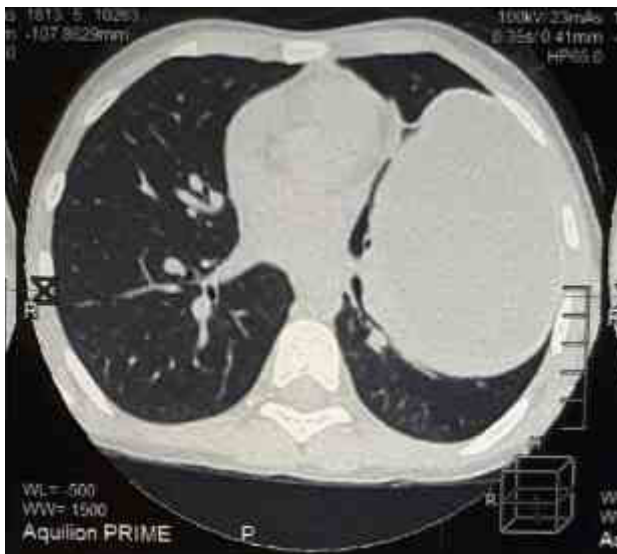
Patient A., 10 years. Preoperative computed tomography. Hydatid cyst in the lower lobe of the left lung
